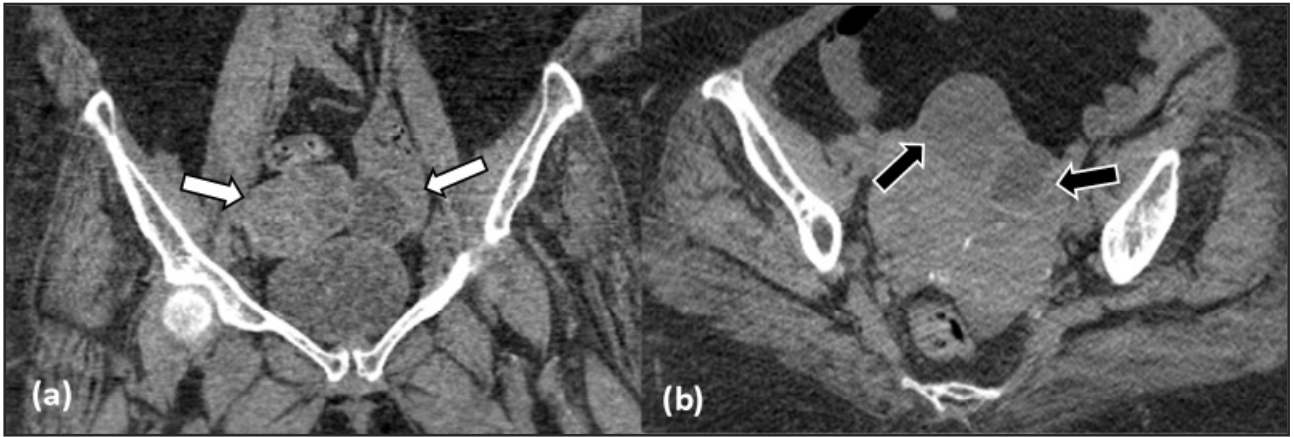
Computed Tomographic Image of the abdomen and pelvis without contrast showing (a) and (b) Bilateral bulky ovaries (White arrow) with bilateral cysts (Black arrow).
